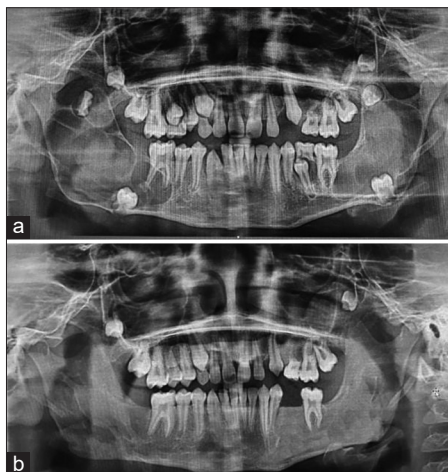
Case 1 - (a) Pre-operative orthopantomogram showing multiple impacted teeth and associated radiolucencies, (b) Cyst enucleation and chemical cauterisation with Carnoy's solution with miniplate in the maxilla, (c) 5-year post-operative orthopantomogram
